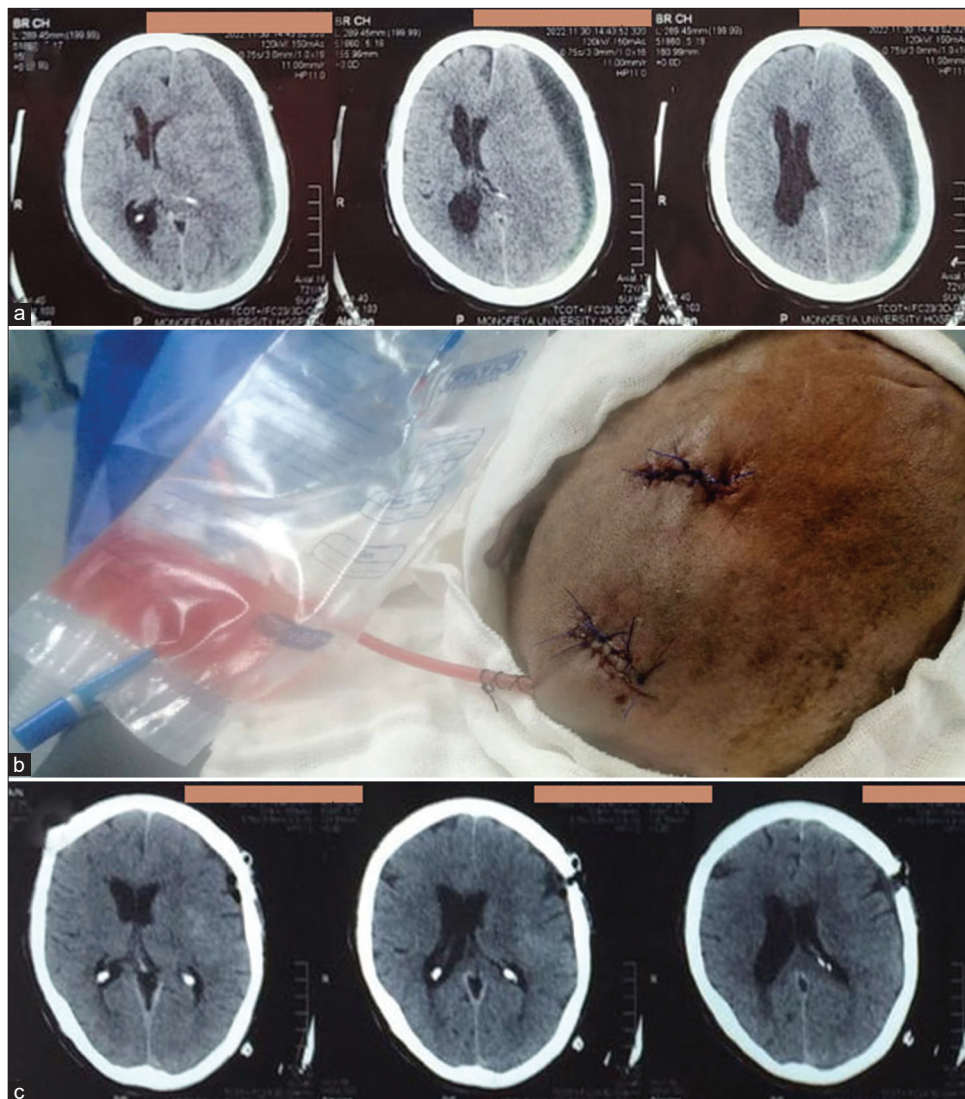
(a) Preoperative computed tomography (CT) of Lt frontoparietal chronic subdural hematomas. (b) Intraoperative picture showing the subgaleal drain connected to a collecting bag after surgical evacuation was done with left frontal and parietal burr holes. (c) Postoperative follow-up CT brain; showing good evacuation and resolving of midline shift.
